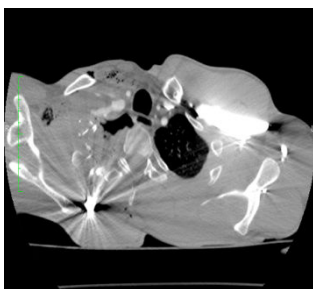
CTA obtained immediately after admission, presenting the injury of the right subclavian artery, hematoma with air collection within the soft tissue and the bullet
